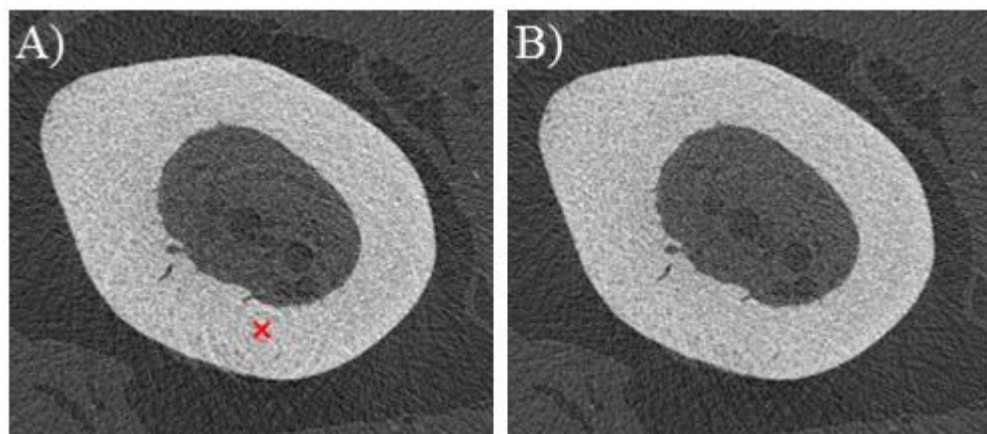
Beam hardening. A) With no software correction applied, beam hardening makes the bone appear artificially denser at the outer surfaces. The red line depicts the region over which an X-ray attenuation profile line is taken. In this profile cupping artefacts can be seen at the outer surfaces, observed as artificially elevated density peaks. B) 40% beam hardening correction applied, gives a flatter profile and more uniform apparent mineral density through the cortical bone.
